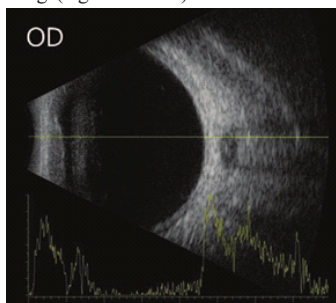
Right eye ultrasound showing choroidal thickening
